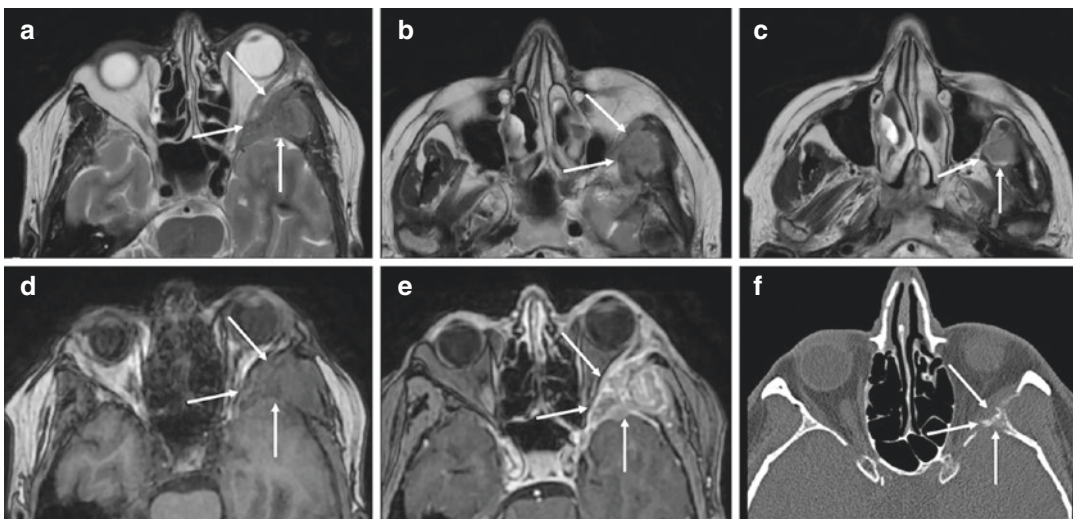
Preoperative axial images of left sphenoorbital meningioma: (a–c) MRI T2-weighted sequences showing the lesion arising from the dura of greater sphenoid wing, with caudal involvement of the inferior orbital fissure and the insertion of the temporalis muscle;
